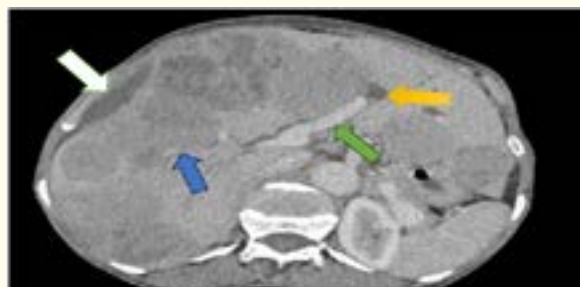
Axial portal venous-phase contrast-enhanced CT image demonstrating multiple hepatic lesions with prominent progressive enhancement (blue arrow). One lesion causes mass effect on the left biliary and portal structures (green arrow), associated with upstream dilatation of the intrahepatic bile ducts, measuring up to 7 mm in diameter (yellow arrow). Additionally, a hypodense subcapsular collection spanning hepatic segments V and VIII is noted, consistent with a chronic subcapsular hepatic hematoma (White arrow).
